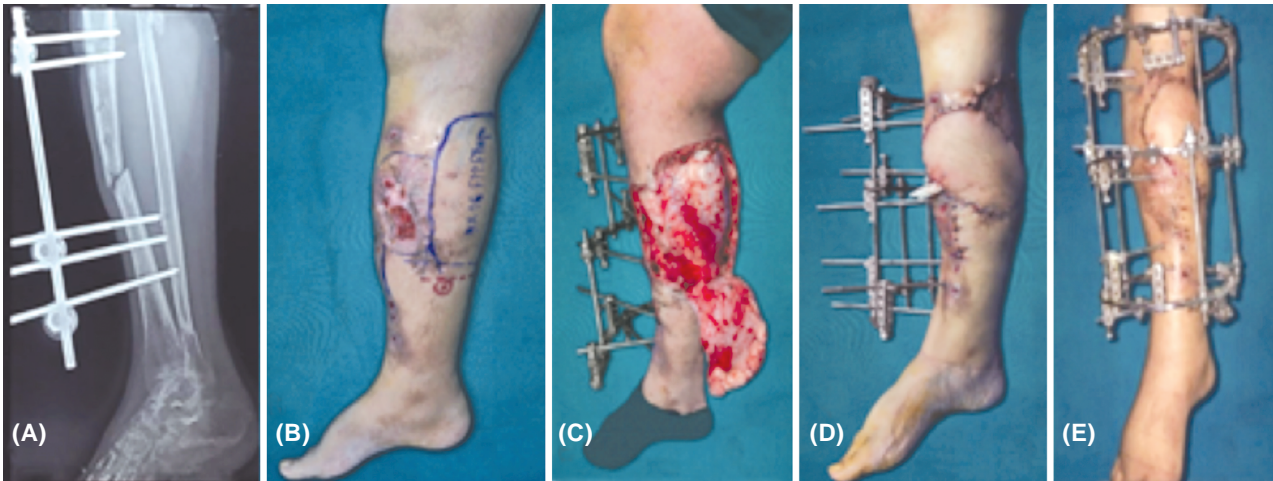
Case No. 5: (A) X-ray showing tibial, fibula fracture and Ex. Fix, (B) Chronic wound, unstable scar and flap design post Ex. Fix removal, (C) Intra-op defect post-excision, flap elevation (Subfascial) and half-illizarov fixation, (D) Post-op defect and donor coverage, (E) Late follow-up showing good healing and contour of flap.
